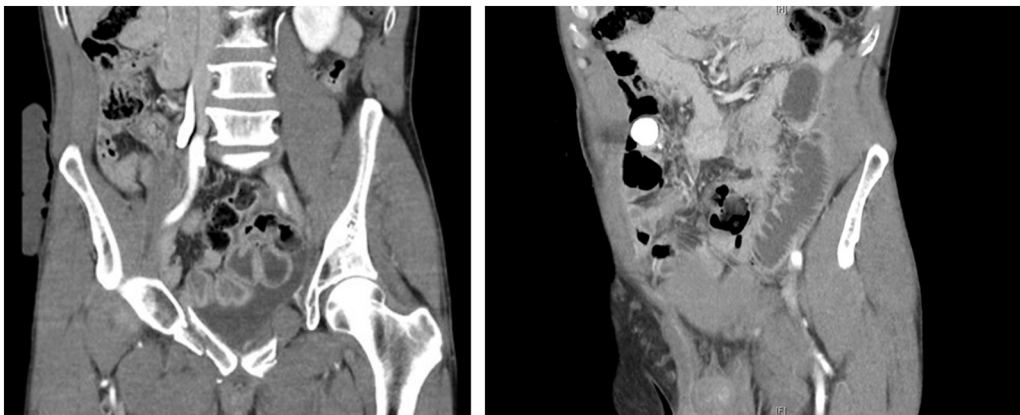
Coronal slices of CT A/P. A) right hemipelvis fracture fragments contacting adjacent small bowel, moderate volume pelvic free fluid. B) Single dilated loop of small bowel in the left iliac fossa, measuring up to 34 mm.
